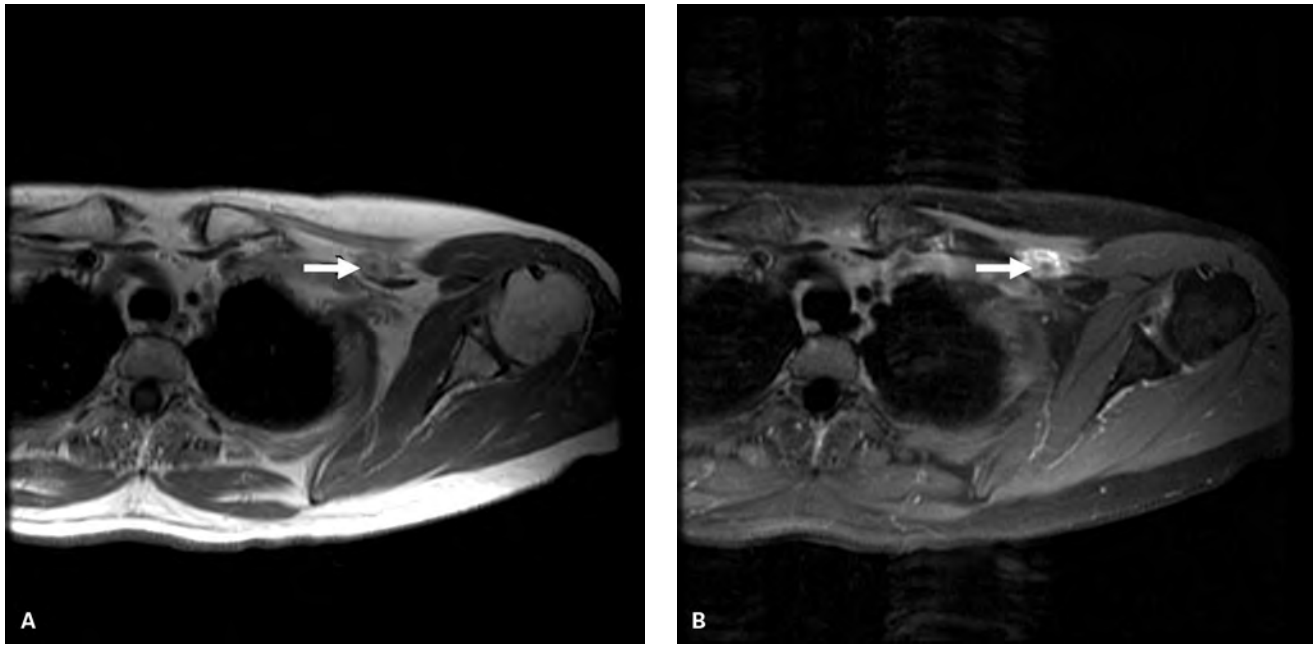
(A) Pre-contrast T1 MRI image of a brachial plexus tumor (arrow). (B) Post-gadolinium contrast T1 MRI image of a brachial plexus tumor (arrow).
